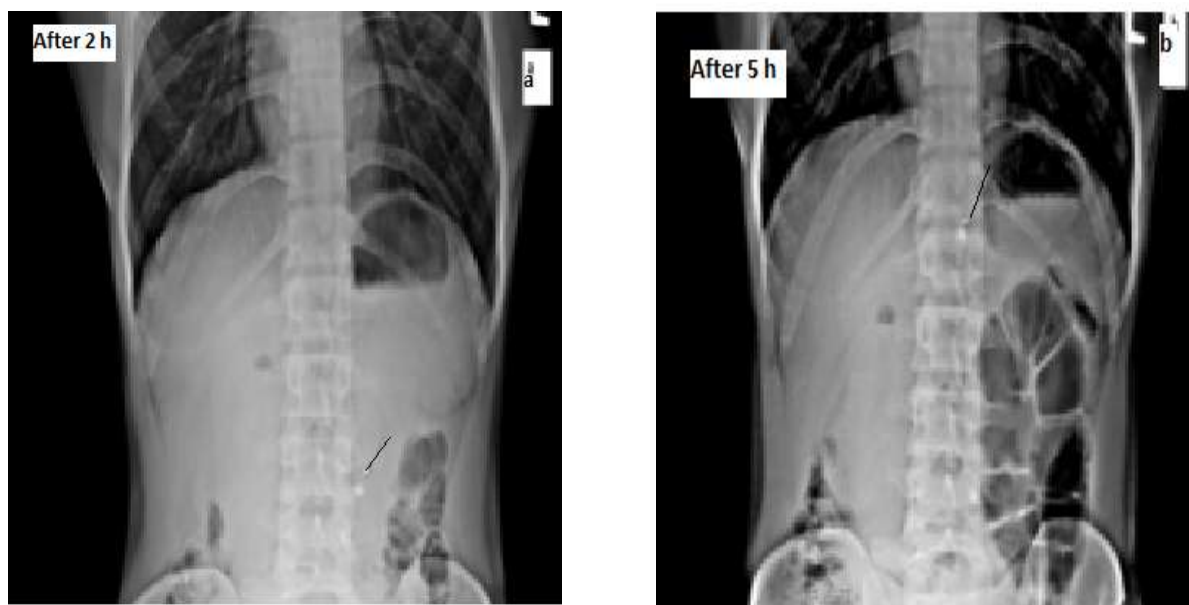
X-ray radiographic images of abdomen after 2 and 5 h of ingestion of BaSO₄ loaded optimized F3 effervescent floating tablet
